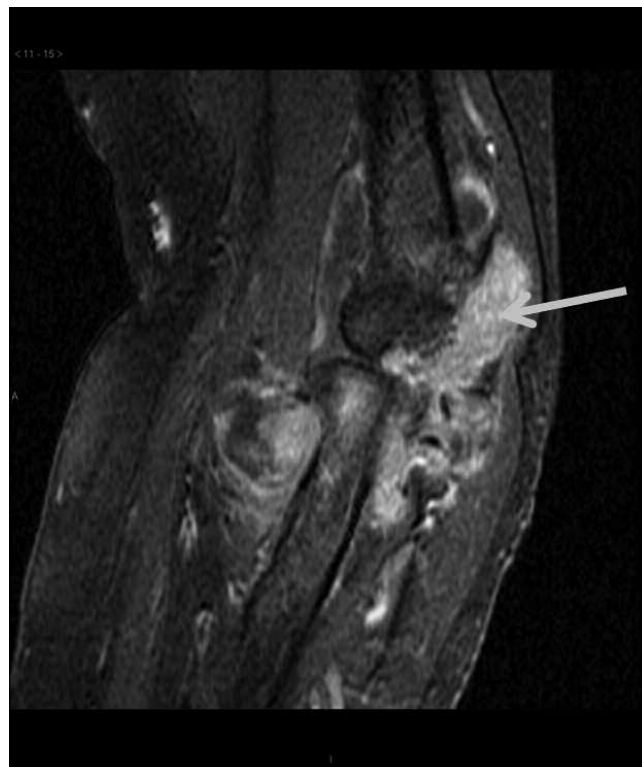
MRI of elbow (sagittal, fat-suppressed post-gadolinium) demonstrates the presence of synovitis (arrow) in Patient 13. MRI: magnetic resonance imaging.
